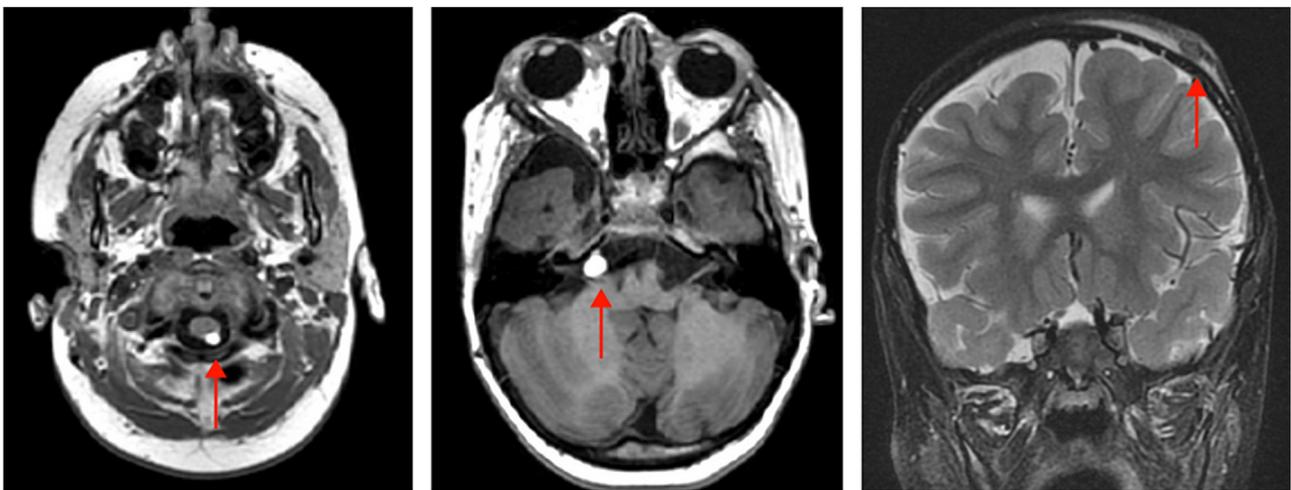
MRI demonstrating a lipoma in the right pontocerebellar cistern and a lipoma posterior to the cervical spinal cord. Subcutaneous tissue thickening is also observed in the right frontoparietal region, clinically corresponding to the alopecia area.
